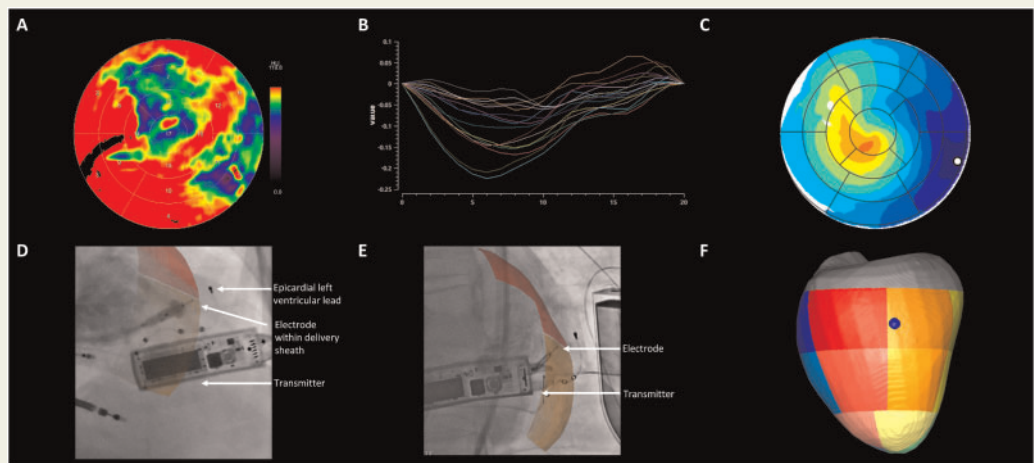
Cardiac computed tomography with dynamic perfusion to successfully guide implantation of a WiSE-CRT system. Cardiac computed tomography with dynamic perfusion was able to successfully guide implantation of a WiSE-CRT system. (A) Images were analysed on a dedicated platform to reveal areas of hypo-perfusion which were represented on a 17-segment American Heart Association model and shown as blue and purple. (B) Mechanical activation showed the latest activation was in the basal inferior segment (light blue). (C) The basal inferolateral segment had a predicted 90% delay in electrical activation time (dark blue). All the pre-procedural information was processed together, and we hypothesized the optimal site for electrode deployment was between the basal inferolateral and inferior segments. (D–F) A three-dimensional shell with the target segments (basal inferior–orange and inferolateral–red) was overlaid onto live fluoroscopy to provide real-time guidance. The greatest improvement in acute haemodynamic response was seen between the basal inferior and inferolateral segments, with areas of hypo-perfusion demonstrating no pacing capture or low increase in acute haemodynamic response. The narrowest QRS duration resulted from pacing in the target segment while pacing in a suspected perfusion defect resulted in a poor acute haemodynamic response and broadening of the QRS duration. Fluoroscopic images in an anterior-posterior (D) and left anterior oblique (E) projection are shown and a three-dimensional model (F) displays the final position of the electrode (blue dot). These all demonstrate the electrode was deployed within the target area.
